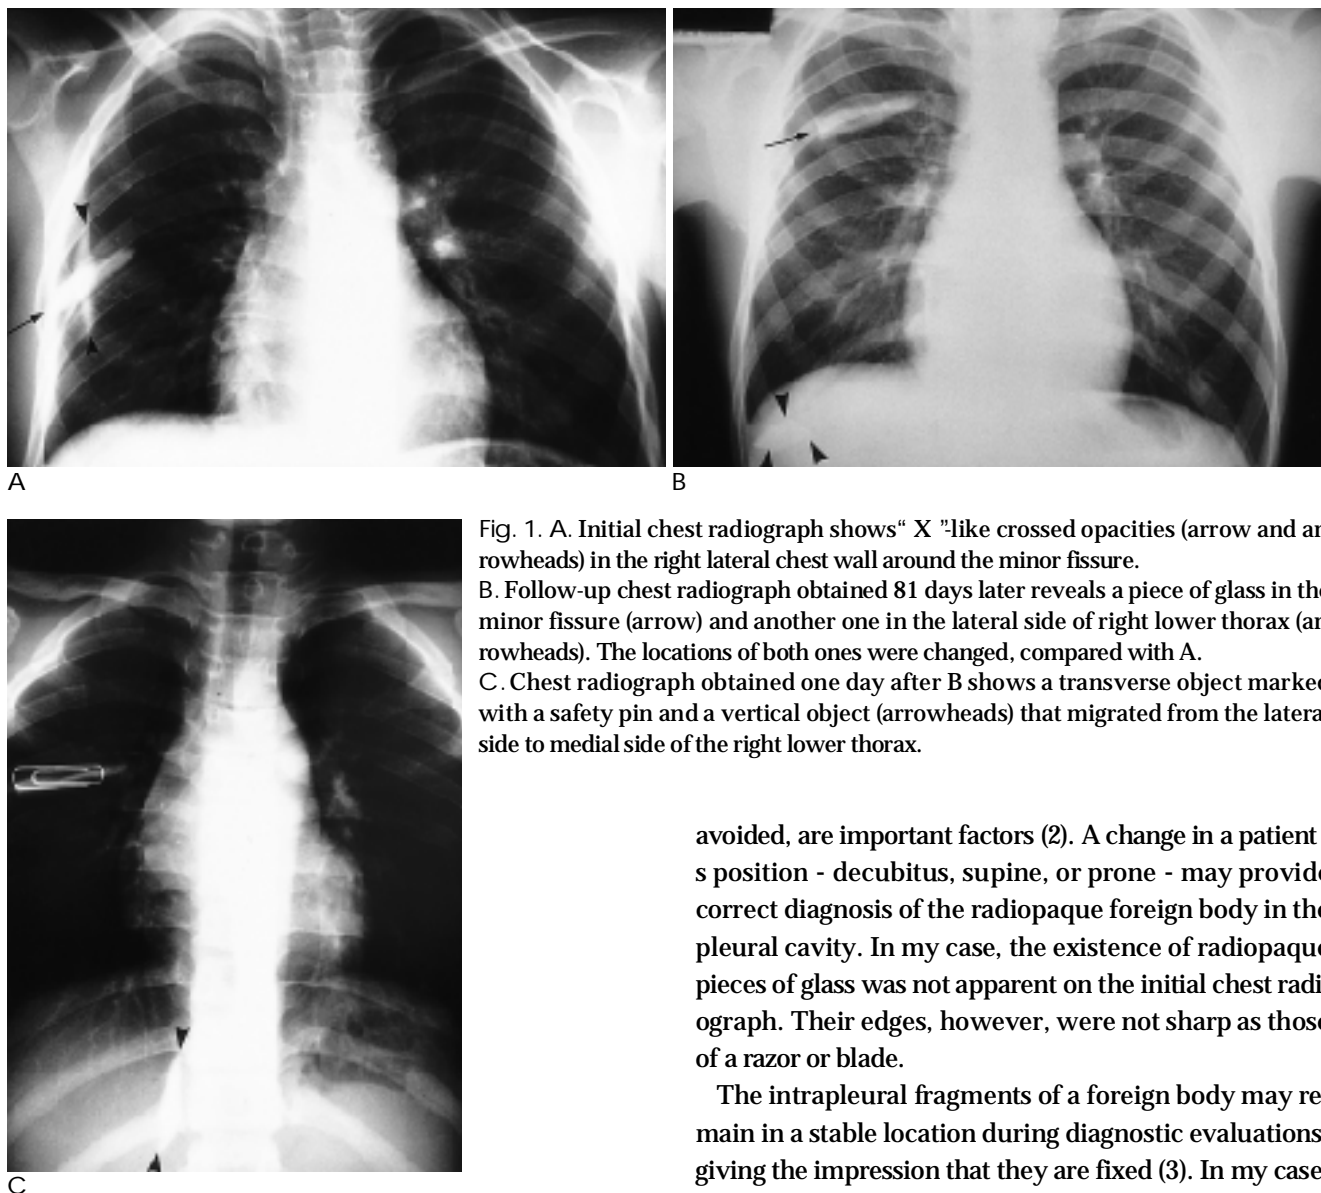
A. Initial chest radiograph shows "X"-like crossed opacities (arrow and arrowheads) in the right lateral chest wall around the minor fissure. B. Follow-up chest radiograph obtained 81 days later reveals a piece of glass in the minor fissure (arrow) and another one in the lateral side of right lower thorax (arrowheads). The locations of both ones were changed, compared with A. C. Chest radiograph obtained one day after B shows a transverse object marked with a safety pin and a vertical object (arrowheads) that migrated from the lateral side to medial side of the right lower thorax.
